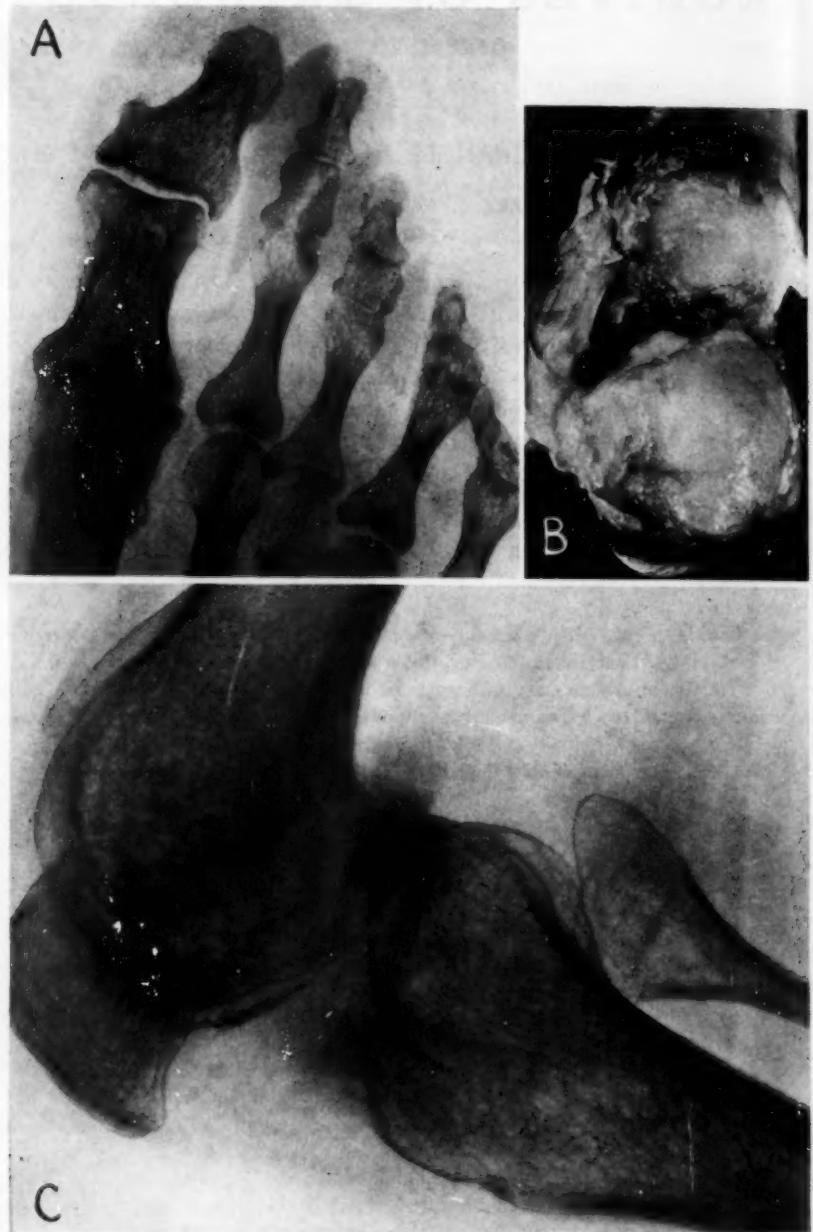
In *A* the narrowed cartilage spaces, the sclerosis of the subchondral bone and the irregular marginal lipping of the joints of the big toe are roentgenographic evidence of degenerative arthritis.
